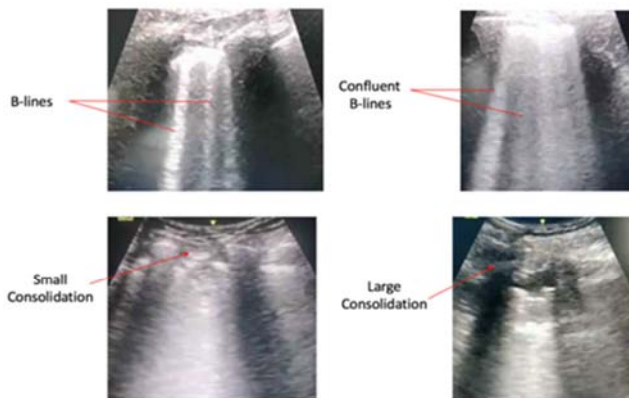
Lung ultrasound in patients with COVID-19 [19].
